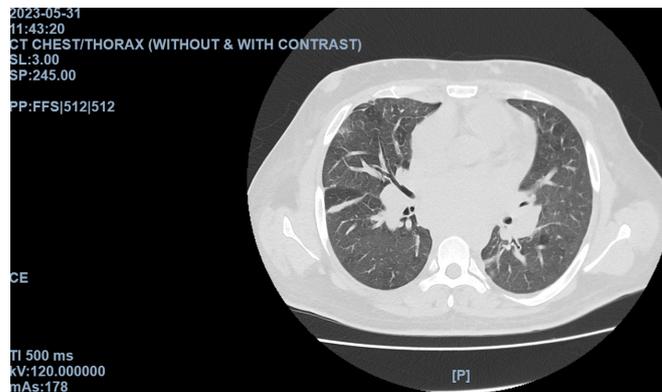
CT Chest/Thorax (Without and With Contrast)
